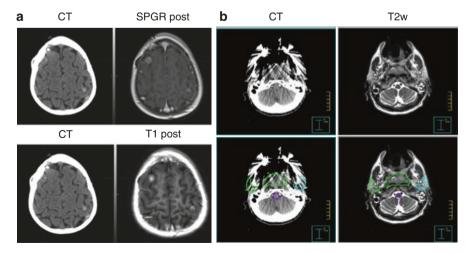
(a) A small brain lesion is invisible in CT images, but can be clearly distinguished in MR images, (b) another patient with a dental filling for which CT images are difficult to provide volume delineation. (Adapted with permission from Das et al., Br J Radiol 2018; 91: 20180505)
